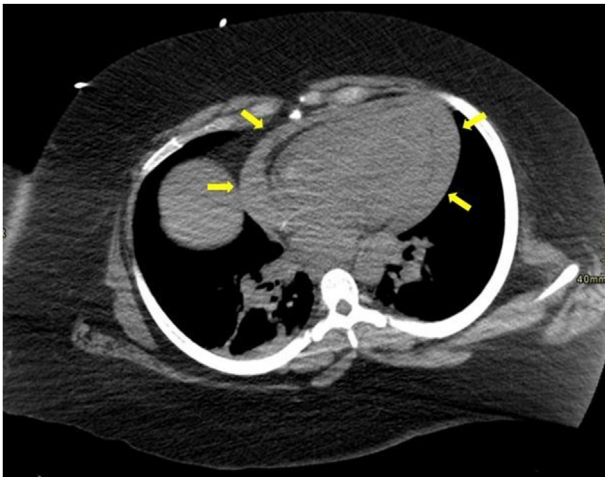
Chest CT of the thorax in axial view without contrast shows a hyperdense pericardial effusion consistent with recent hemorrhage (yellow arrows).
